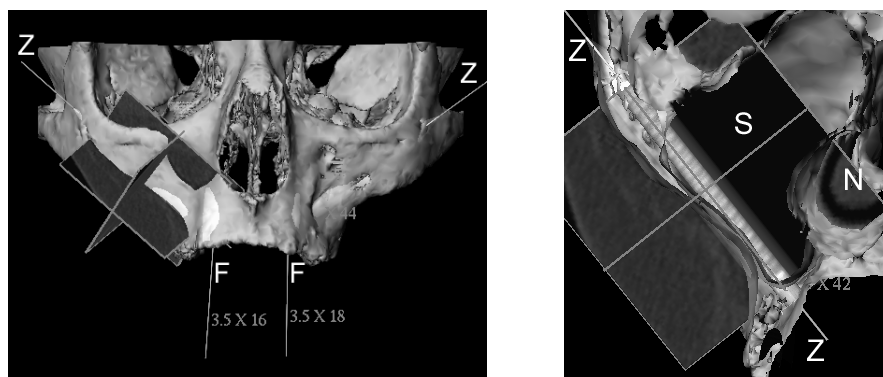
Left:* Two zygoma fixtures are shown at Z, and two frontal alveolar implants at F. *Right:* a CT reslice along a planned implant's axis is co-visualized with extracted bone structures. Note the nearby nasal cavity (N) and the course of the implant along the cortex of the sinus (S).
